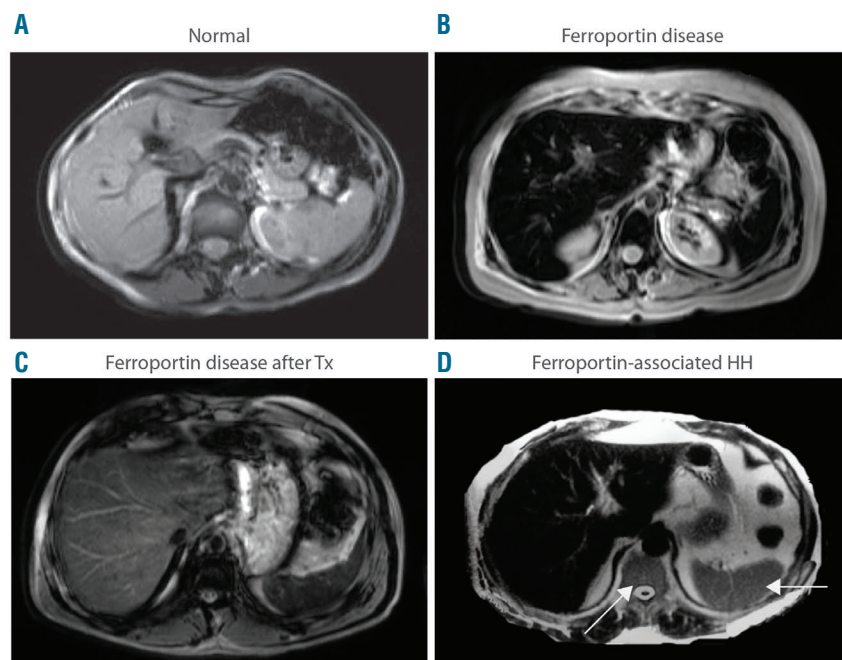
Abdominal magnetic resonance imaging (MRI) pattern of Ferroportin Disease (FD). MRI scans. T2*-weighted gradient-echo sequences were used to detect iron accumulation. (A) Normal subject. (B) FD. (C) FD after completion of phlebotomy program (note that excess iron is still detectable in the liver and spine in spite of normal serum ferritin and transferrin saturation levels). (D) Ferroportin-associated hereditary hemochromatosis: iron accumulation involves only the liver and spares the spleen and spine (arrows).
